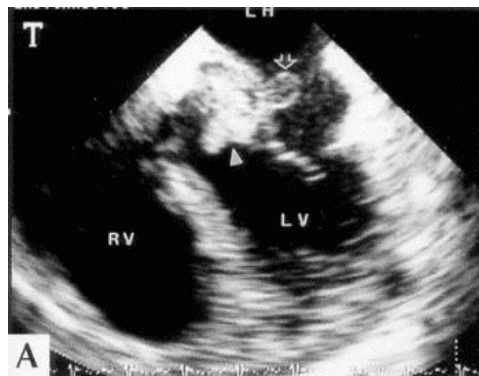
Vegetation on aortic valve as seen in transesophageal echocardiography
